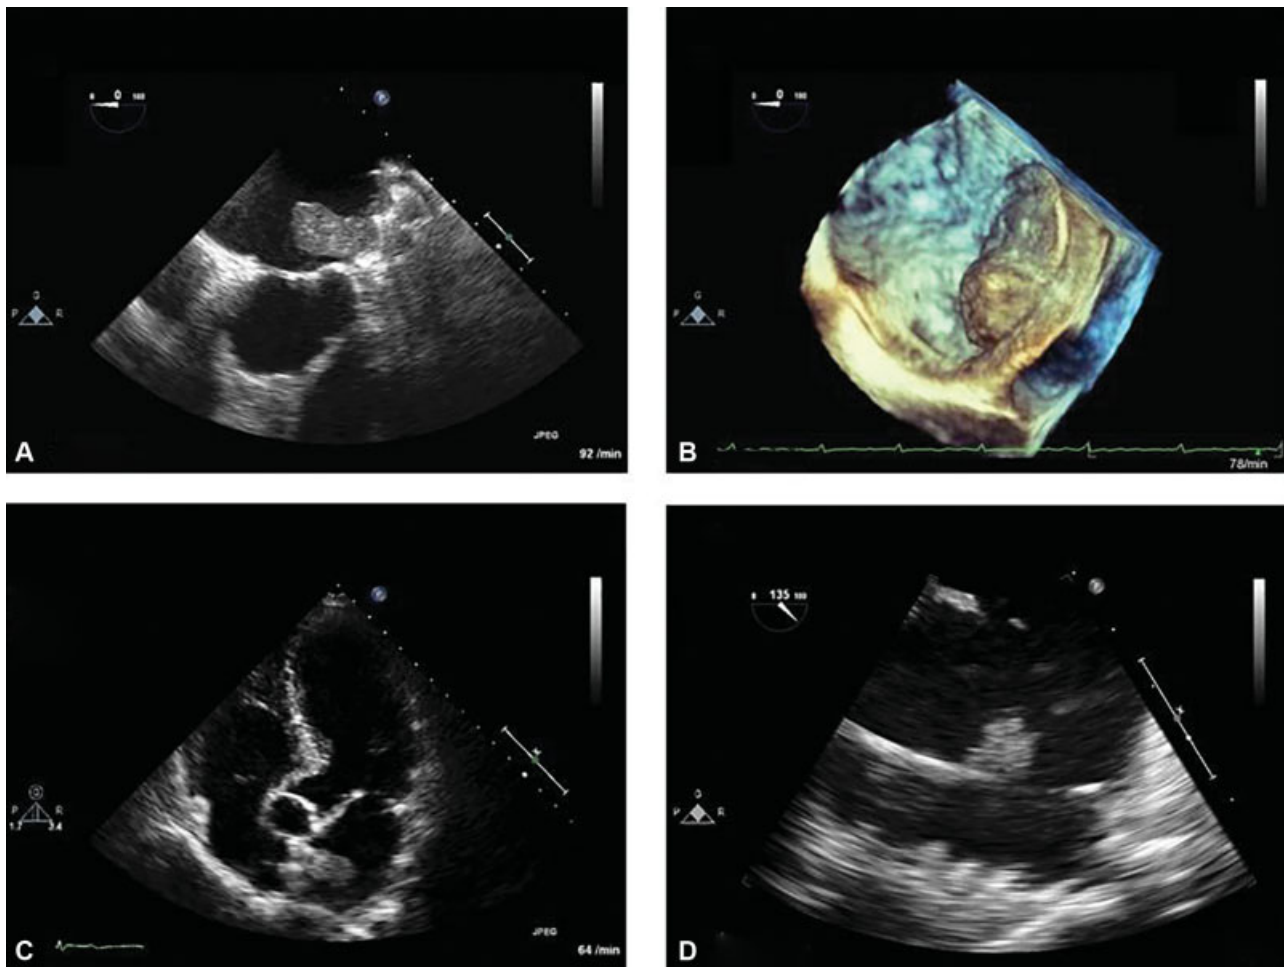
(A) Two-dimensional (2D) transesophageal echocardiography (TOE) images and (B) three-dimensional (3D) TOE images of device-related thrombosis (DRT) 6 weeks after left atrial appendage (LAA) occluder (Amplatzer Cardiac Plug) in a 70-year-old patient. (C) DRT 3.5 months after patent foramen ovale (PFO) occluder implantation in a 68-year-old patient. (D) Pacemaker-associated thrombosis on atrial lead in a patient with sick-sinus- syndrome.
